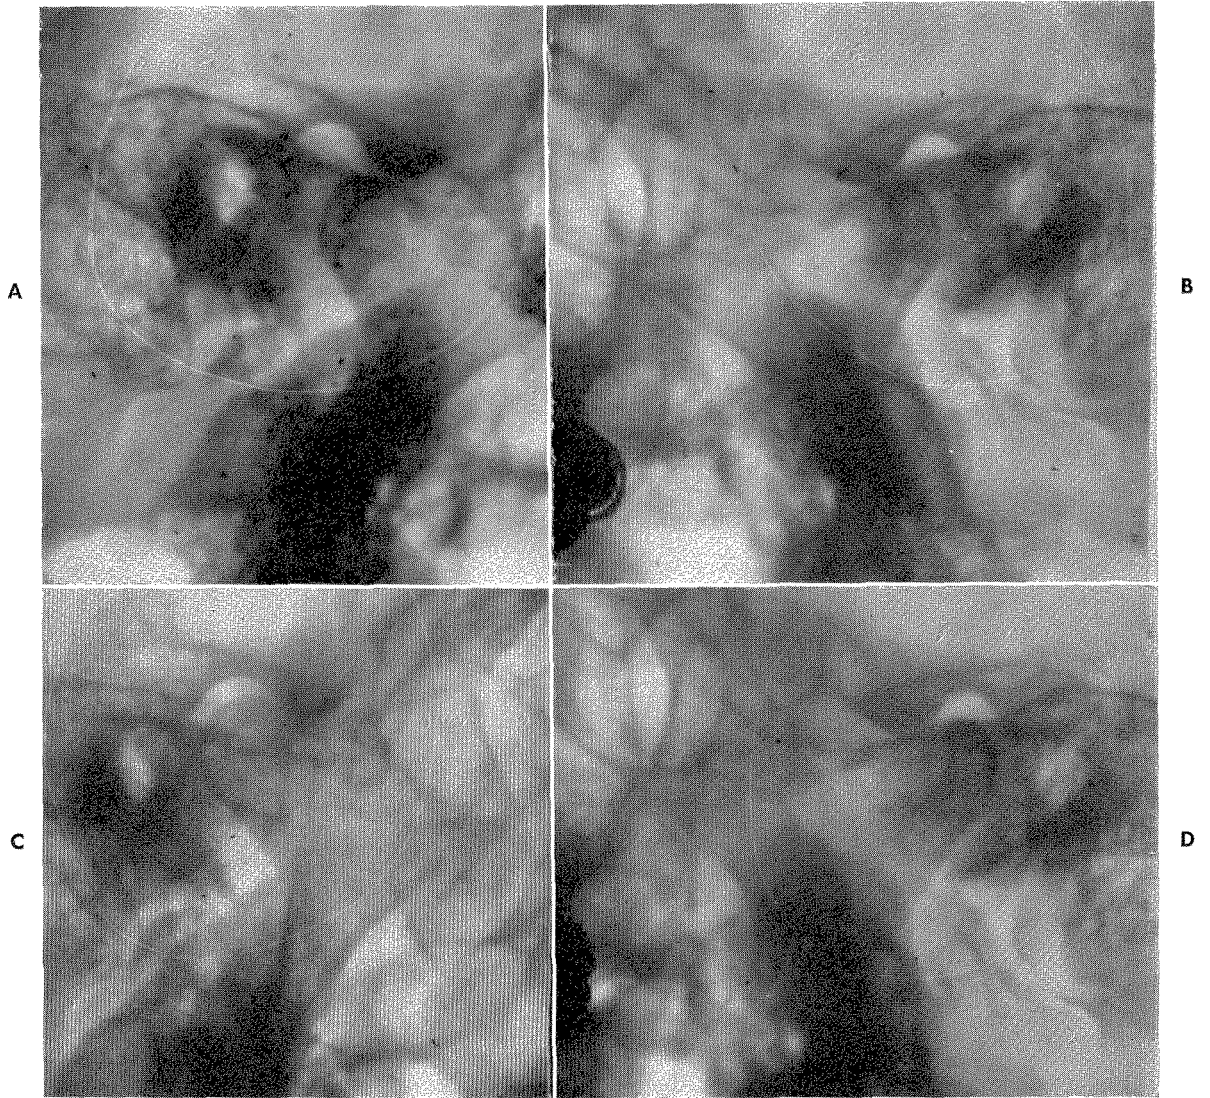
Roentgenograms of the right and left temporomandibular joints at the start of treatment. A and B, Bite plate in place. The condyle is displaced downward and forward. C and D, Bite was lowered. After treatment splints were inserted. The condyles are in a more favorable position.
